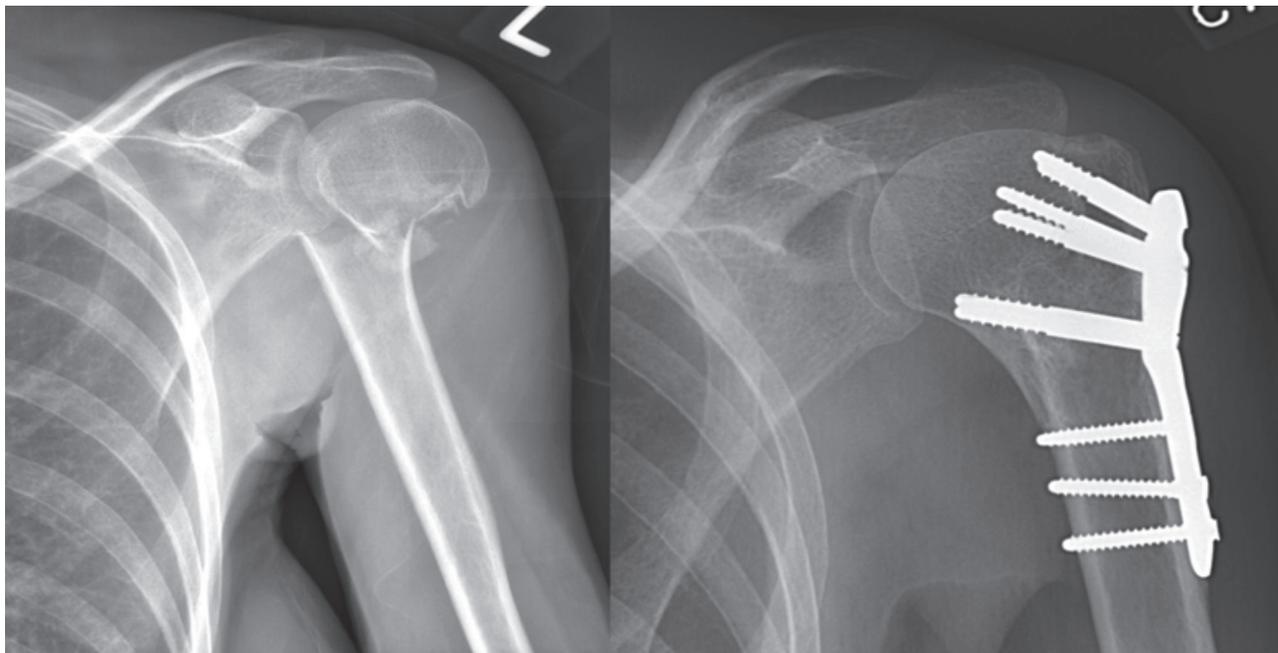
Anteroposterior radiographs demonstrating a proximal humerus fracture at time of injury (left) and 1 year after ORIF (right).
